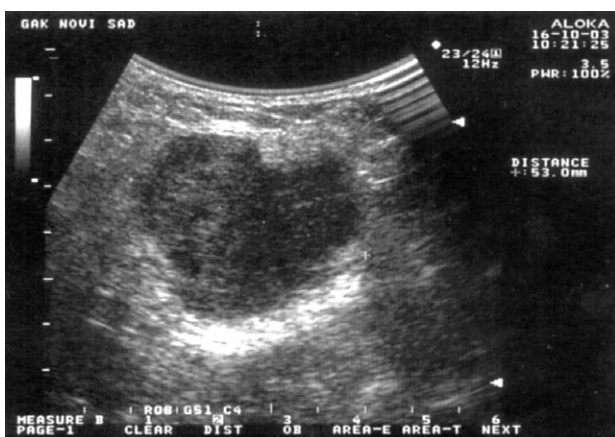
Sonographic appearance of endometrial carcinoma recurrence in the region of m. rectus abdominis.
